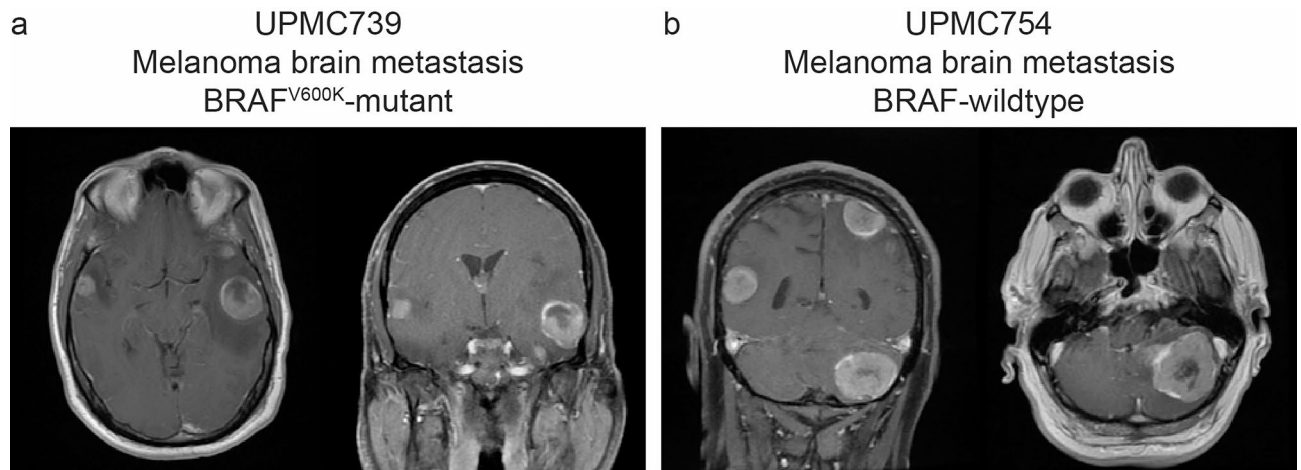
Preoperative axial and coronal T1 post-contrast magnetic resonance imaging (MRI) of (a) Patient 1 (UPMC739) revealing a large left temporal lobe melanoma metastasis, and (b) Patient 2 (UPMC754) revealing a large left cerebellar melanoma metastasis.
